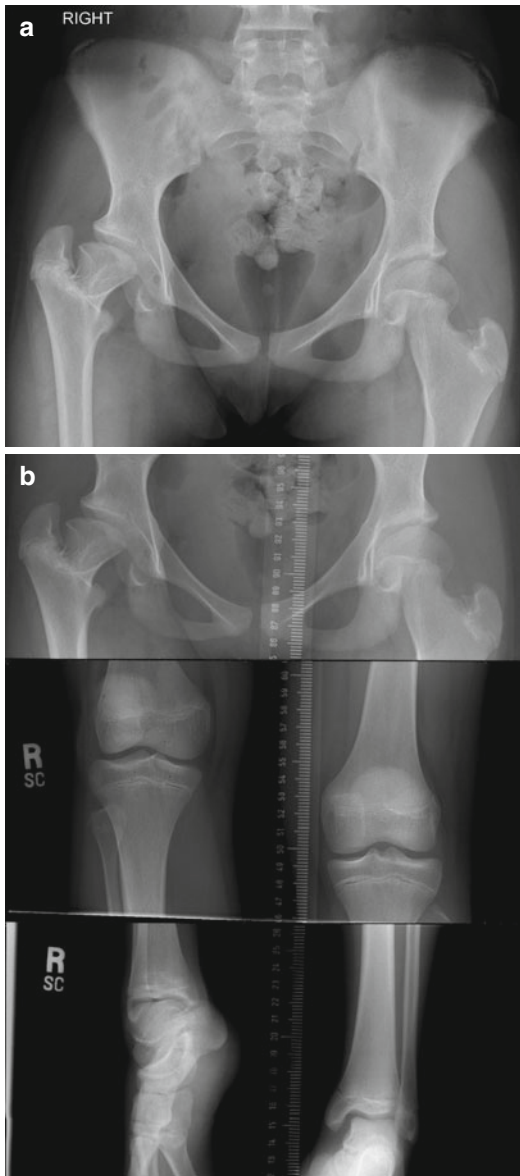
Leg length discrepancy in a child with multiple femoral arterial cannulations in infancy. (a) The AP pelvis radiograph at age 13 years demonstrates complete arrest of the right proximal femoral epiphysis resulting in coxa vara with a small femoral head and a reduced articulo-trochanteric distance. The left proximal femur demonstrates lateral physeal tethering with a subsequent coxa valga deformity. (b) The scanogram demonstrates a marked leg length discrepancy, the right shorter than the left
